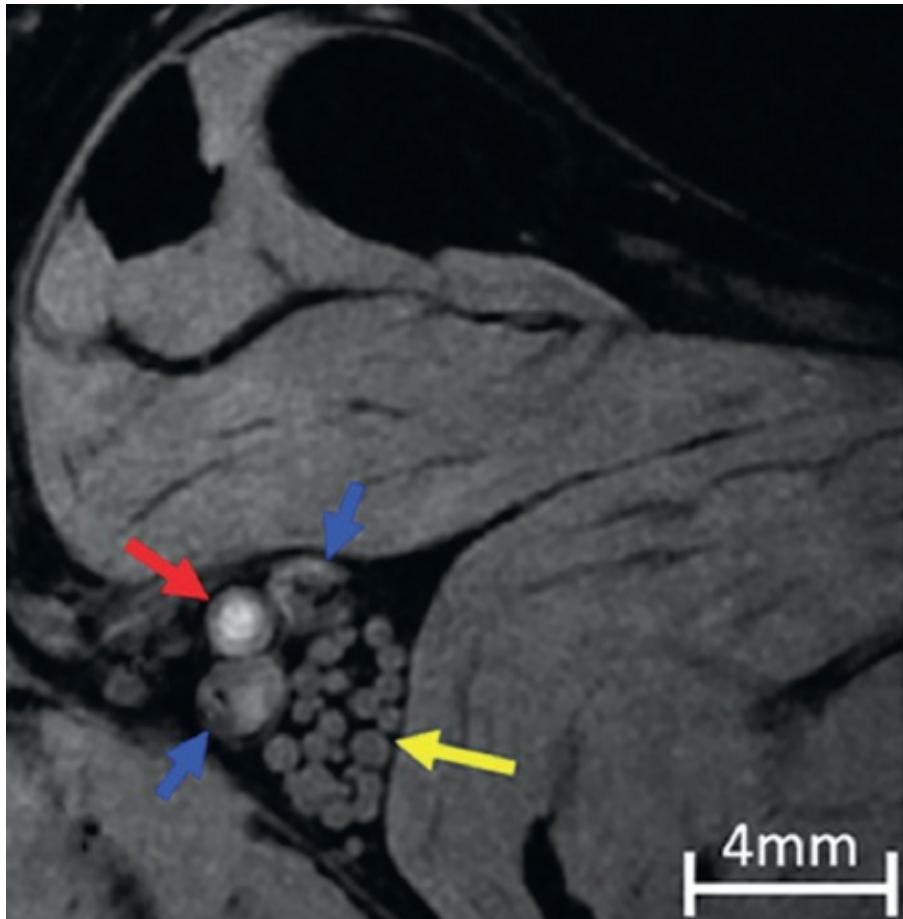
Individual fascicles of the tibial nerve are clearly identified at high resolution on 7T MRI, marked by the yellow arrow. Posterior tibial artery is marked by the red arrow and posterior tibial veins are marked by the blue arrows. (Modified from Yoon D, Biswal S, Rutt B, et al. Feasibility of 7T MRI for imaging fascicular structures of peripheral nerves. *Muscle Nerve*. 2018;57(3):494-498. Copyright © 2017 Wiley Periodicals, Inc. Reprinted by permission of John Wiley & Sons, Inc.)
